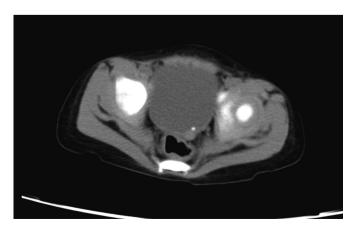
CT scan indicates a bladder foreign body resembling grains of rice.
